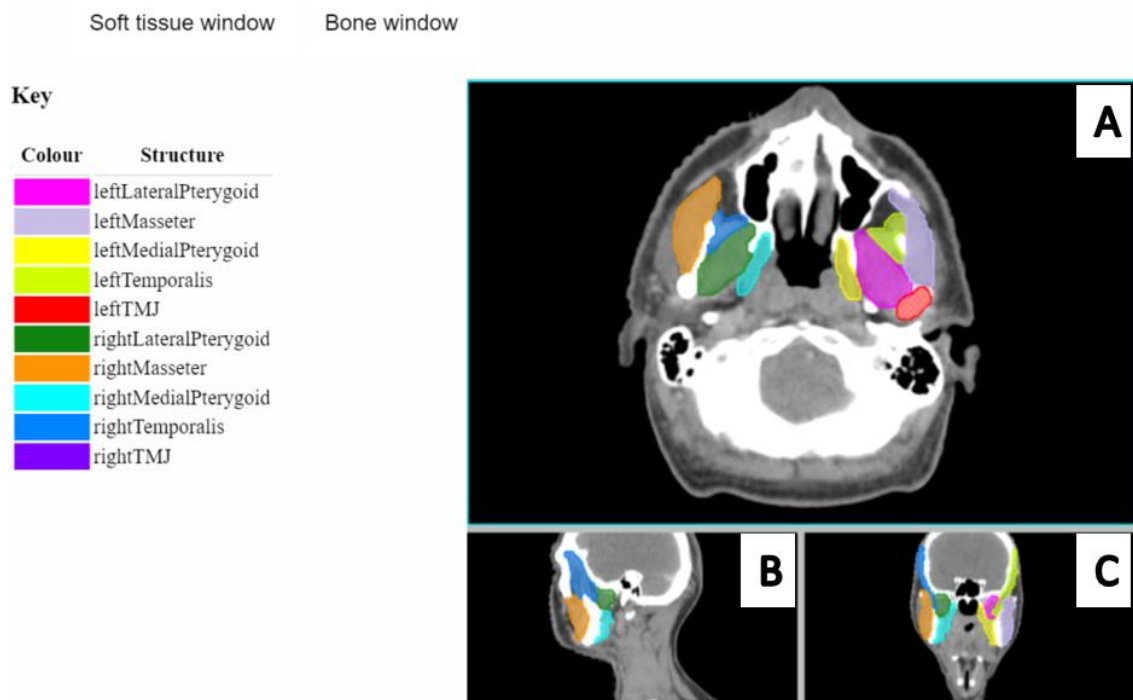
Overview of the masticatory muscles' atlas. Axial (A), sagittal (B) and coronal (C) slices are shown. The right TMJ is not visible on the CT slice shown in Figure 4.0. <https://bit.ly/trismusatlas> (to access the webpage please open with google chrome version 56 or opera version 43).
